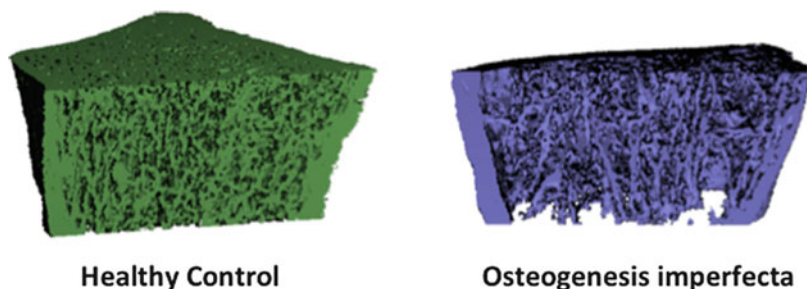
Bone microstructure by high-resolution peripheral quantitative computed tomography. Bone microstructure in a healthy subject (*green*) and an adult patient with osteogenesis imperfecta type IV (*purple*). Severe deteriorations of trabecular bone are a valuable explanation for low sclerostin levels in OI
